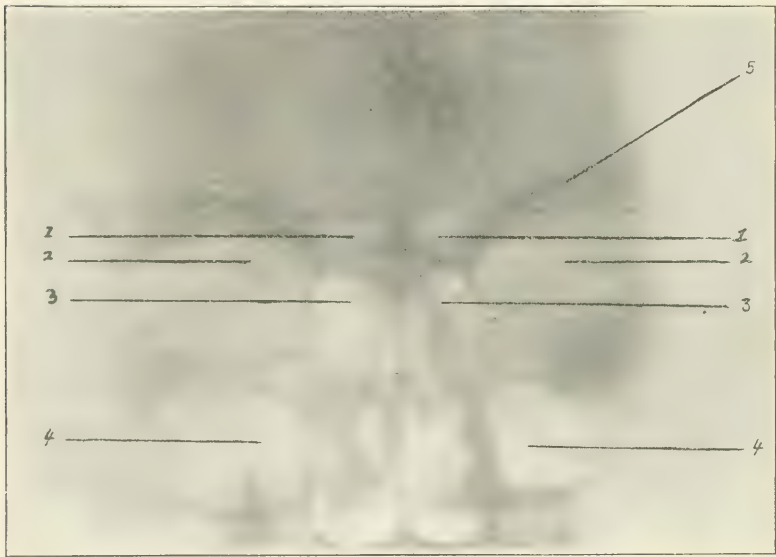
Young girl, W. S., age 12 years. Anteroposterior view showing normal sinuses. Patient had orbital abscess, O.S., caused by falling from a chair. Discharged well in two weeks. X-ray of accessory sinuses negative. Frontal sinuses small, above root of nose. 1. Frontal sinus. 2. Orbital regions. 3. Ethmoid region. 4. Antrum of Highmore. 5. Dark line given by wings of sphenoid bone.
